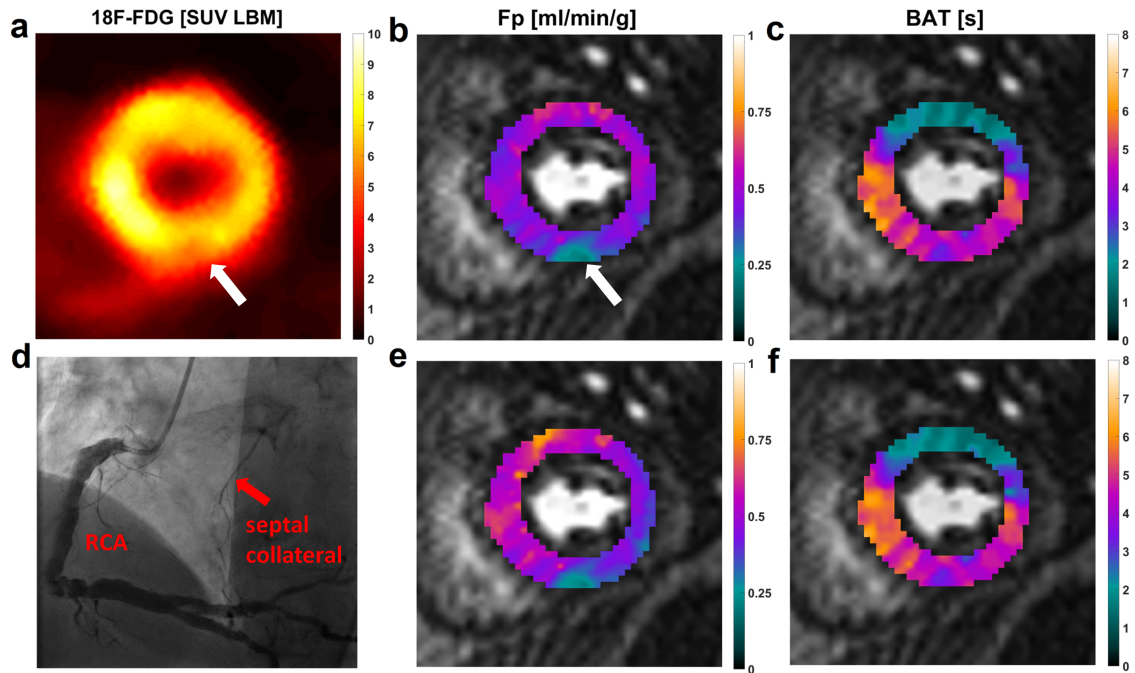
Results of the ^{18}F -FDG PET scan (a) confirming metabolic integrity of the collateralized septal territories with the exception of a small inferior region, also exhibiting a small defect in plasma flow F_p (b). Panels on the right show results of the DCE-MRI analysis with (b/c) and without SCIC and saturation correction (e/f). Angiography results show the septal collateralization (d).
